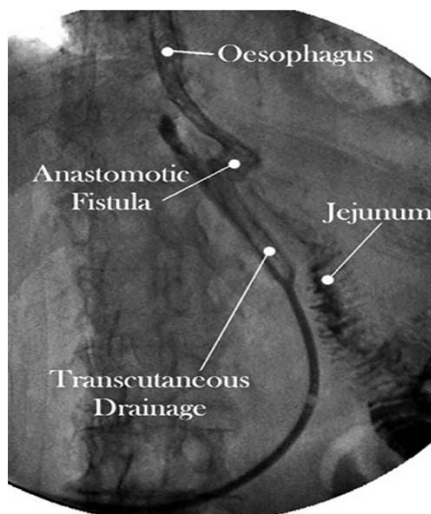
Radiographic image showing leak
